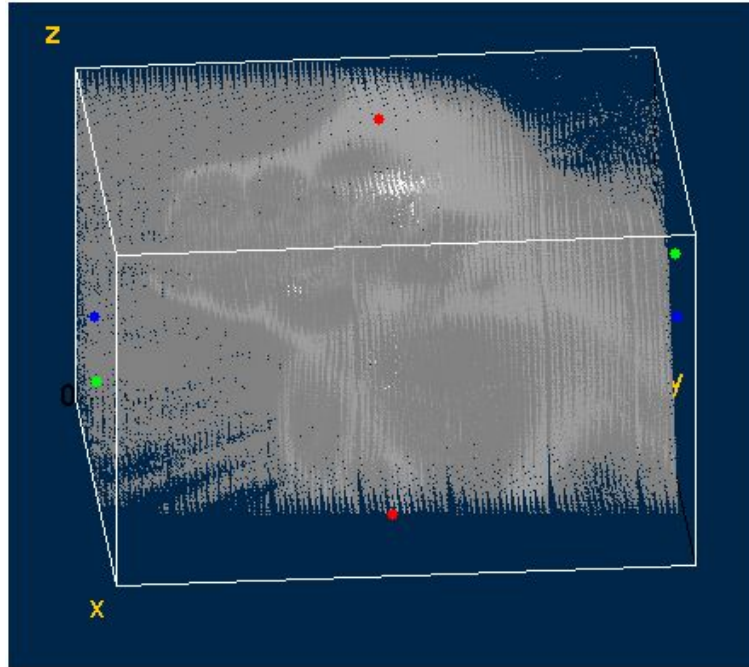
CT slices concatenated to form a volume
